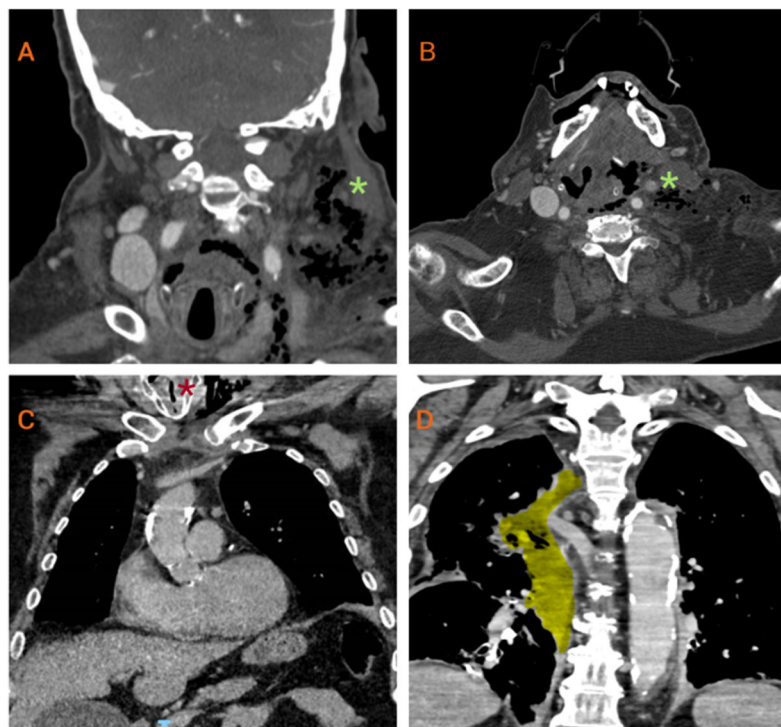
Cervicothoracic CT scan demonstrating: (A) subcutaneous emphysema with air bubbles in the left laterocervical region (green asterisk); (B) cervical abscess accompanied by extensive thrombosis of the left internal jugular vein and ipsilateral dural venous sinuses (green asterisk); (C) severe airway deviation with a minimum glottic lumen diameter of 5 mm (red asterisk); and (D) cervical collection with mediastinal extension (highlighted in yellow), responsible for right-sided mediastinitis and significant airway compromise.
